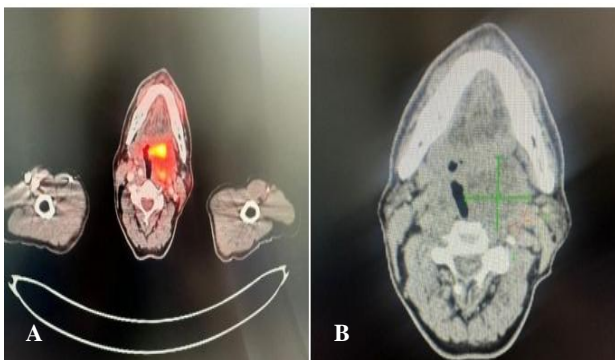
(A & B): Positron emission tomography-computed tomography (PET-CT) image showing parapharyngeal tumor in left parapharyngeal space.
